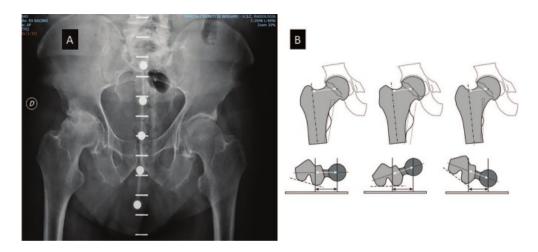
(a) Example of suboptimal radiograph due to incorrect femoral rotation and pelvic misalignment. (b) Impact of femoral rotation on offset evaluation
